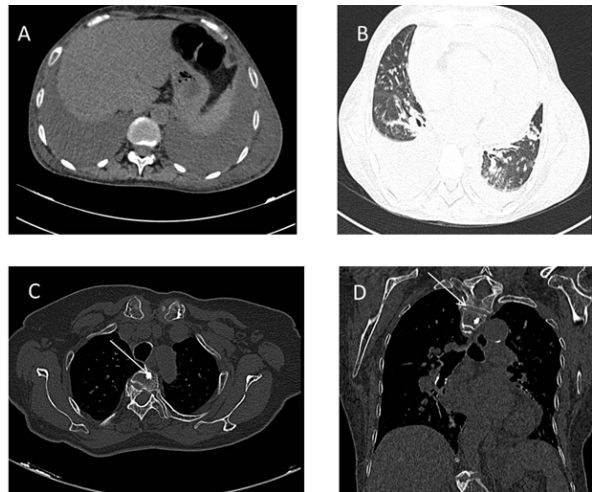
Axial (A,B,C) coronal (D) mediastinal, lung , bone window images of HRCT chest showing incidentally detected bone island in D2 vertebral body (arrow) in 45 year old female, who routinely underwent HRCT for Broncho pneumonia. Mean attenuation bone island was 1250 HU.
